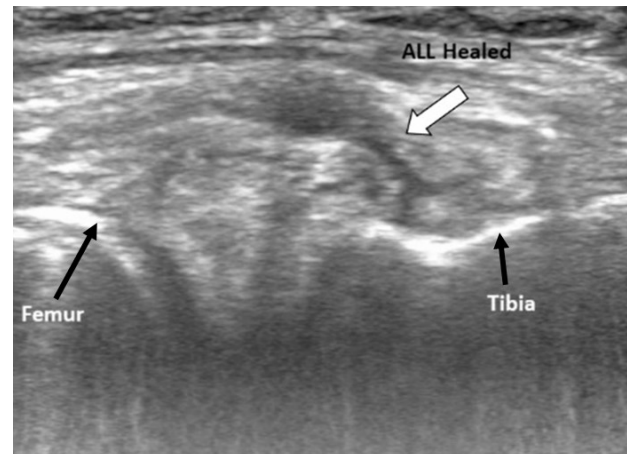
Ultrasound findings post PRP injection showed restoration of normal appearance of the ALL with 80% of the ligament fibers visualized
